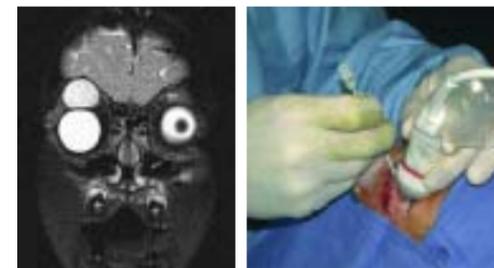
MRI of 4y/o female with large supra-orbital dermoid cyst eroding and elevating the orbital roof
